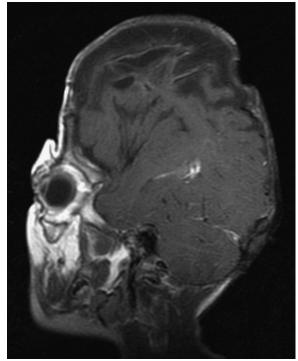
Magnetic resonance image at 8 months after shunt.
